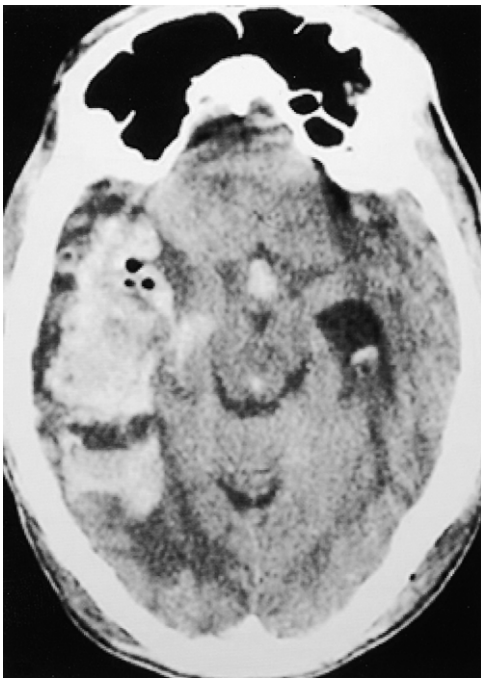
A 54-year-old man with AIDS underwent a stereotactic biopsy of a brain lesion. After surgery, the patient had neurologic deterioration, and a CT scan demonstrated a large right temporal intraparenchymal hemorrhage.
